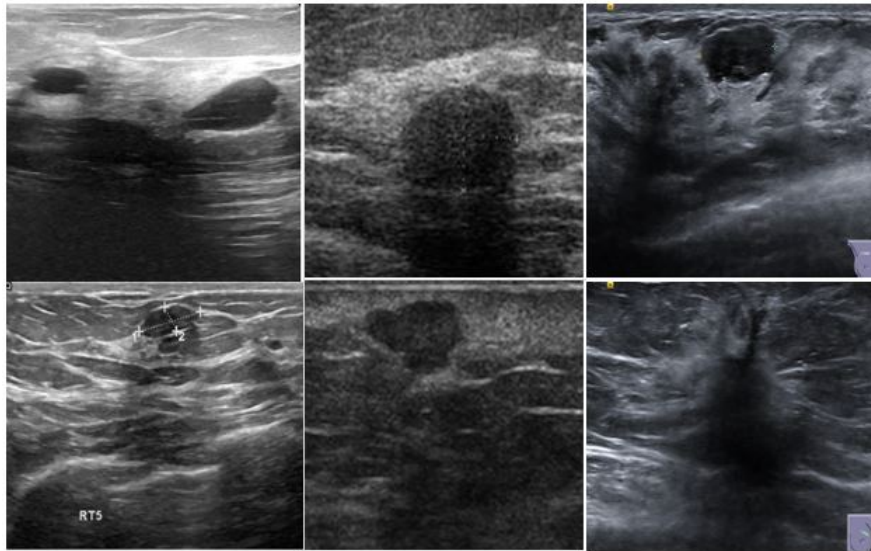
US Images - Top(benign) and Bottom(Malignant): Left- Breast Ultrasound Images dataset, Middle- Breast Ultrasound Dataset, Right- Breast Ultrasound Lesion Segmentation Dataset
